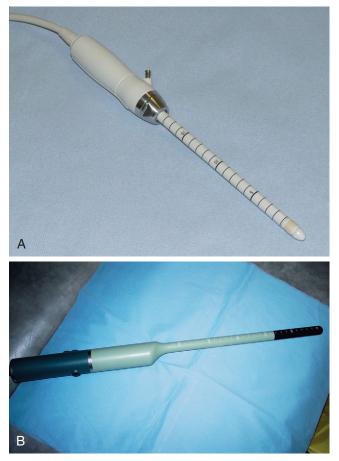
Probes for ultrasound examination of the anal sphincter complex. A, Hitachi EUP-R54AW-19/33 electronic radial probe. B, B and K medical 1846 probe. (A, Courtesy of Hitachi Medical Systems, Wellingborough, UK; B, Courtesy of BK Medical, Herlev, Denmark.)
